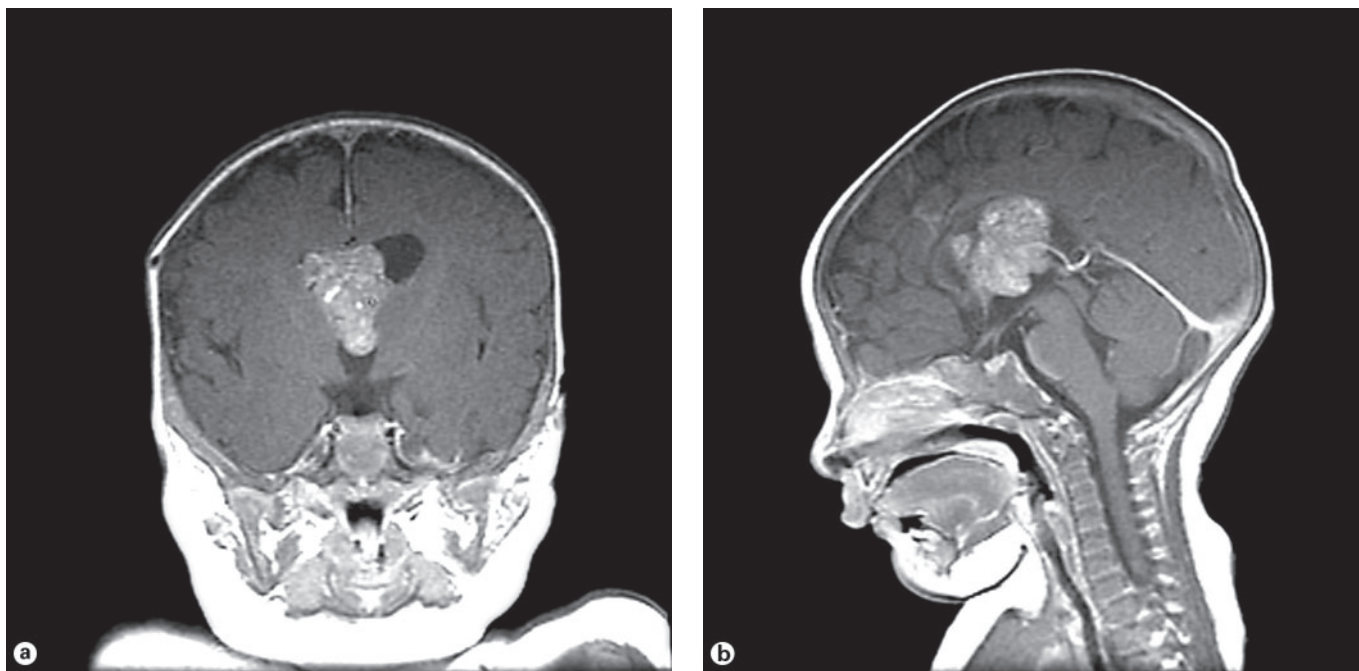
Second preoperative coronal (a) and sagittal (b) MRI 4 weeks after presentation shows resolution of the hematoma and a more distinct enhancing mass centered within the velum interpositum, extending upward into the lateral ventricles and inferiorly into the third ventricle.
